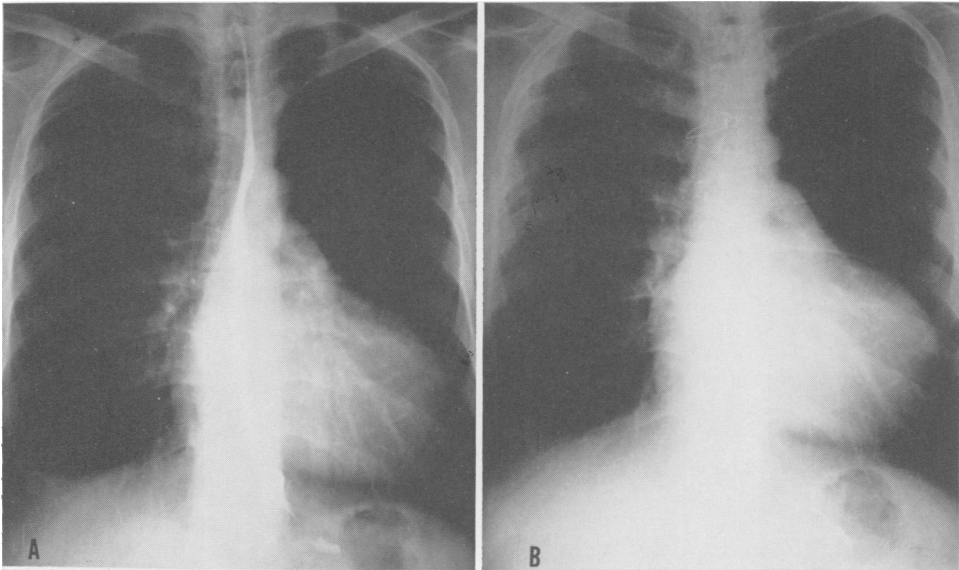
Preoperative (A) and postoperative (B) chest x-rays of patient I. R.
